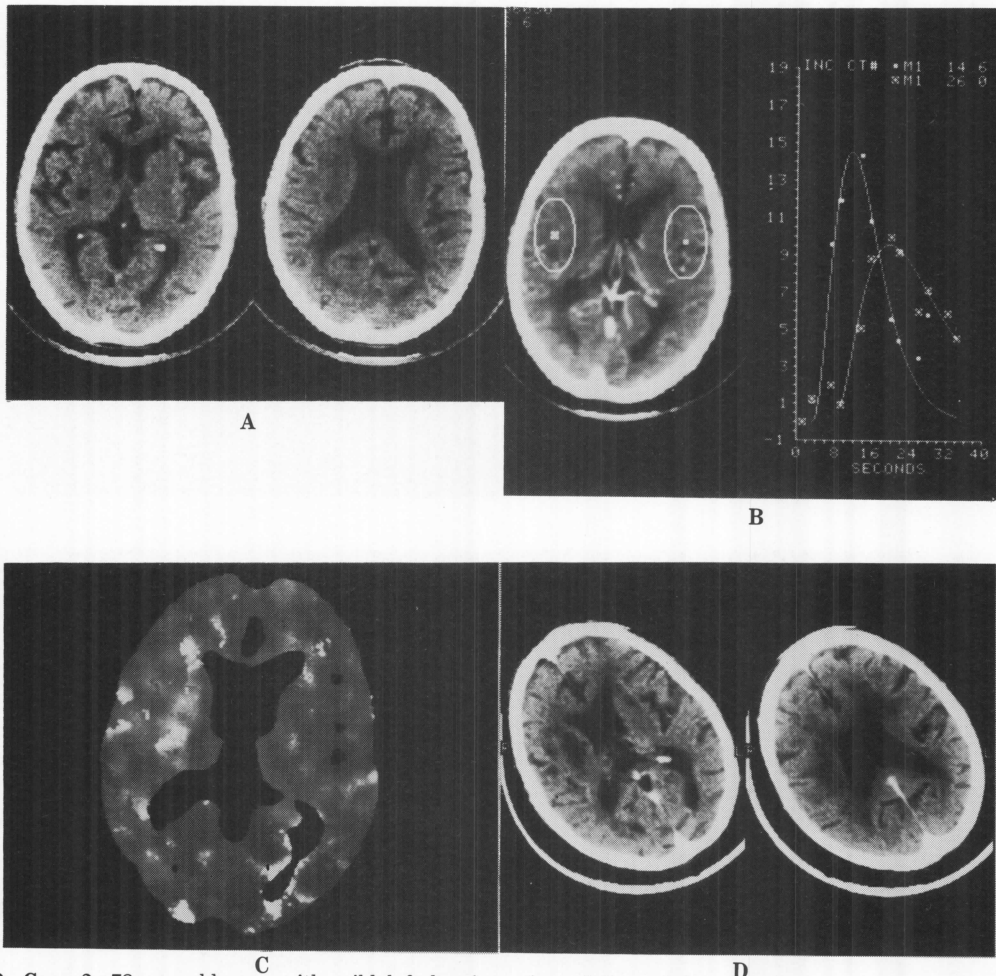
Case 2, 78-year-old man with mild left hemiparesis and dysarthria. A: Conventional CT scans do not reveal definitive findings responsible for the symptoms. B: Analysis of time-density curves shows a 11.4 second difference in mean transit time (M1) between the two hemispheres, the right more prolonged than the left. C: The M1-functional image reveals delayed circulation in the right hemisphere and absence of perfusion in the right putamen. D: Follow-up CT scans performed six days later demonstrate dissolution of the right putamen.
